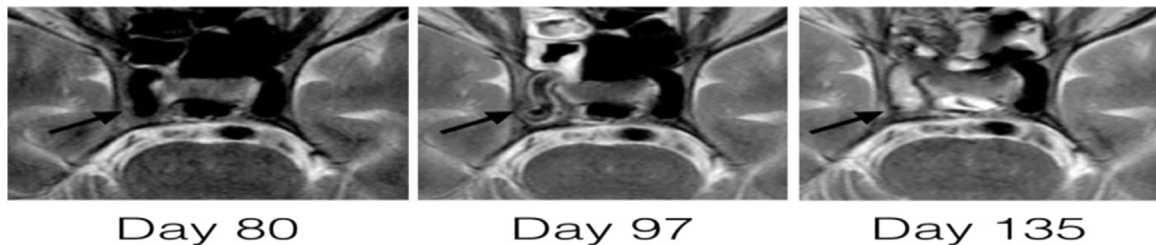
MRI showing the evolution of the right ICA (arrow) infiltration at the level of cavernous sinus. On day 80 there is no visible infiltration and vessel walls are normal. On day 97, vessel walls are thick and the flow in the ICA seems to be slower. On day 135, the whole right ICA is occluded by non-enhancing material which was later proven to be of fungal origin.
